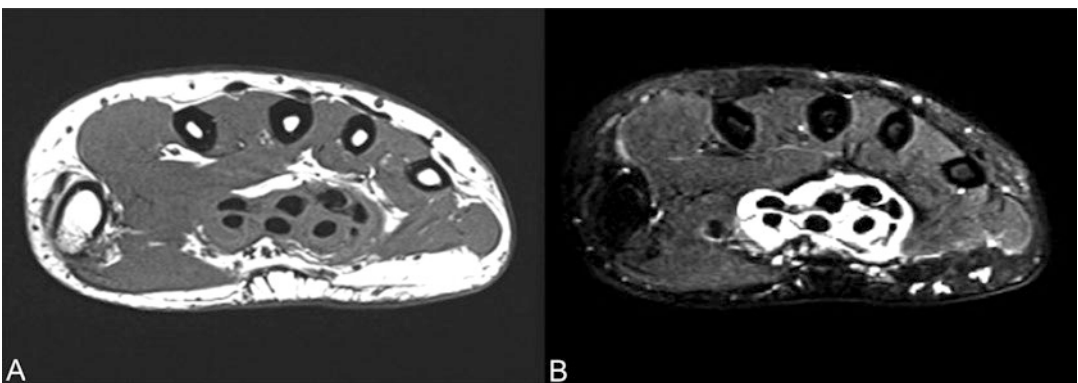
Axial MRI T1 (a) and T2 fat saturation (b)—tenosynovitis of the flexor tendons in rheumatoid arthritis
